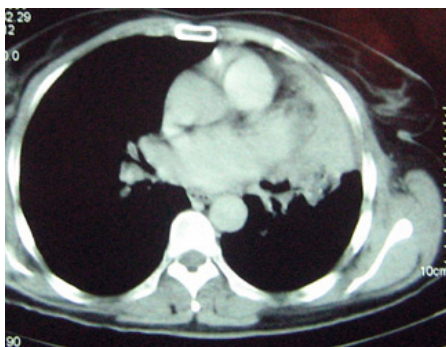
Chest CT-scan showing a bronchial tumour mass of the left superior lobe.
